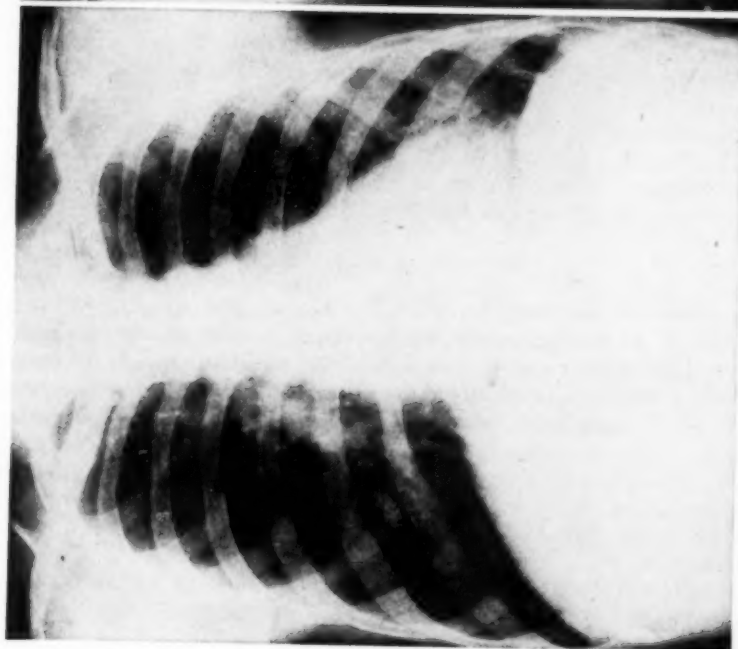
Linear and patchy infiltration with predilection for lung bases, demonstrating most typical radiographic picture.
